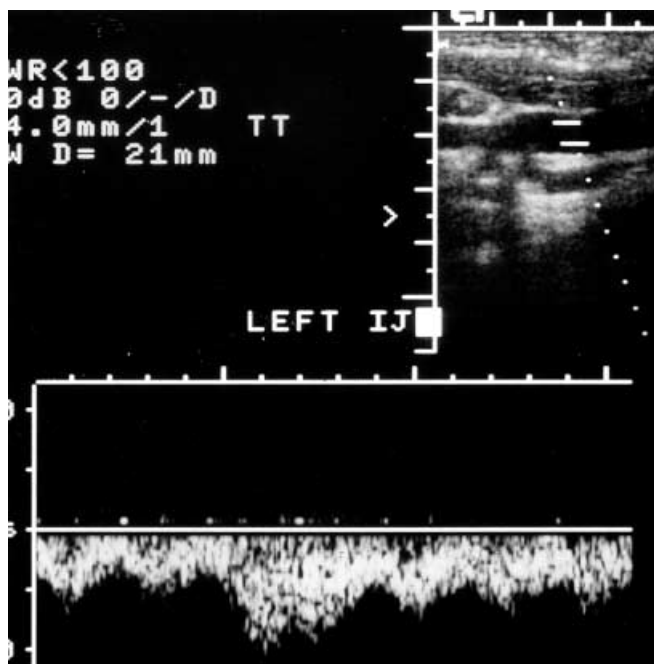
Doppler ultrasound scan demonstrating patent interval jugular vein
